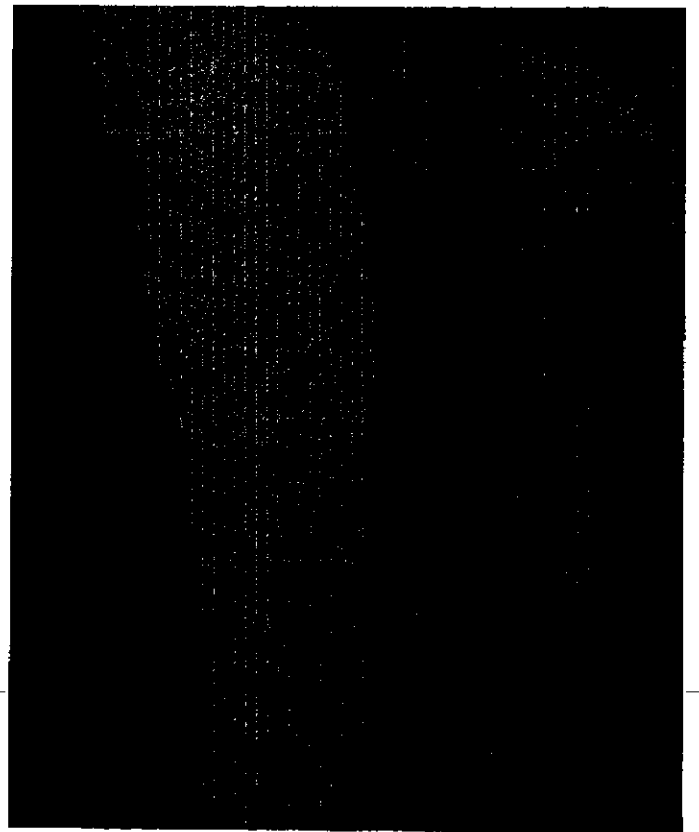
Radiographic result 10 months after surgery
